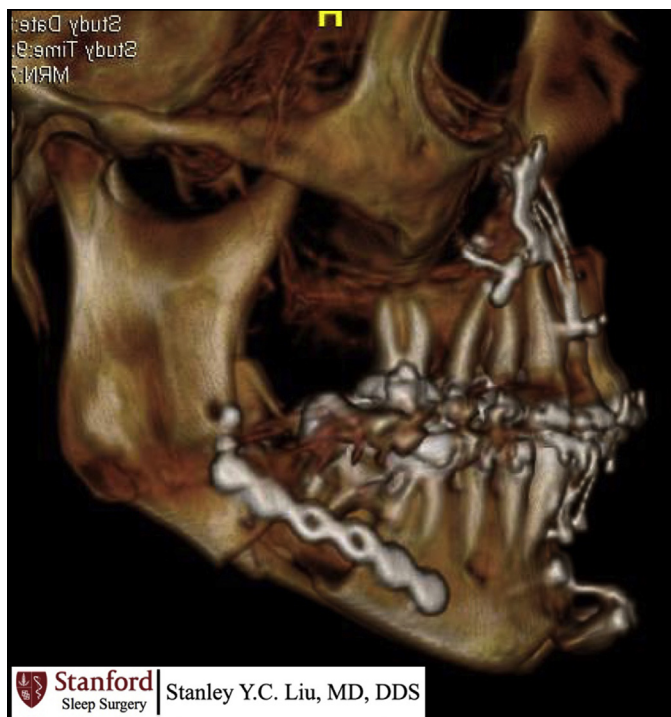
Postoperative CT after MMA. Suspension wires are removed 6 weeks after surgery.
